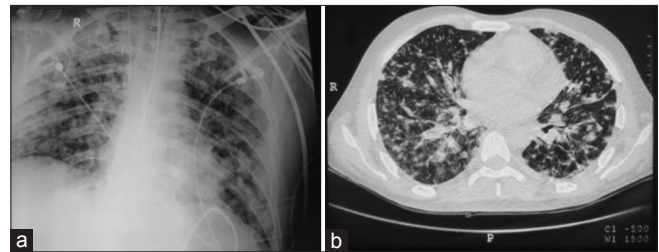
(a) Chest X-ray at admission to intensive care unit suggestive of bilateral diffuse alveolar infiltrates with well-preserved costo-phrenic angles and cardiac size. (b) Computed tomography chest at admission suggesting bilateral ground glass opacities with reticulation and small nodules distributed in both lung fields suggestive of acute respiratory distress syndrome
